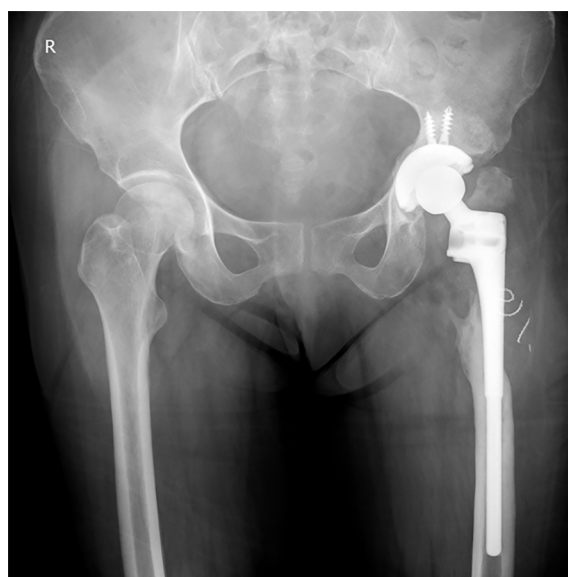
X-ray film, anteroposterior plane. The left artificial hip had a severe proximal femoral defect.
